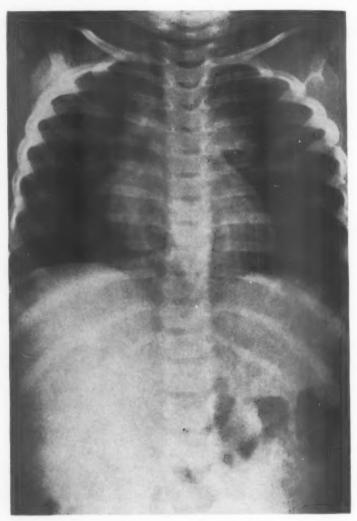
Case 8: Roentgenogram after surgical removal of the bronchiogenic cyst. Note well expanded left lung.
